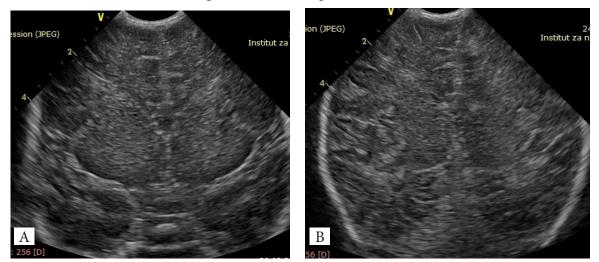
Head ultrasound showed effacement of the cerebral sulci, compressed slit-like ventricles, and narrowing of the interhemispheric fissure (A and B: coronal images)
